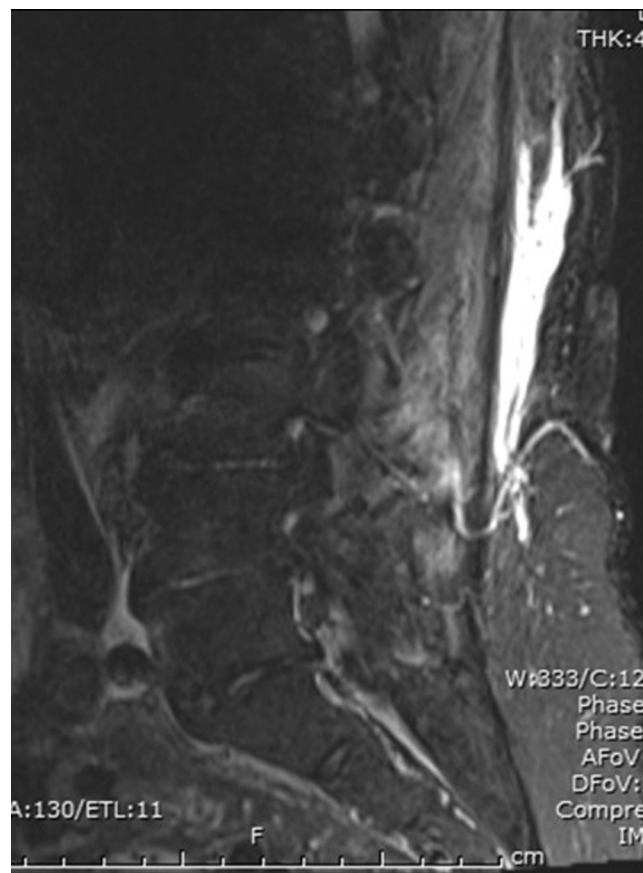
Sagittal MRI of lumbar spine.
